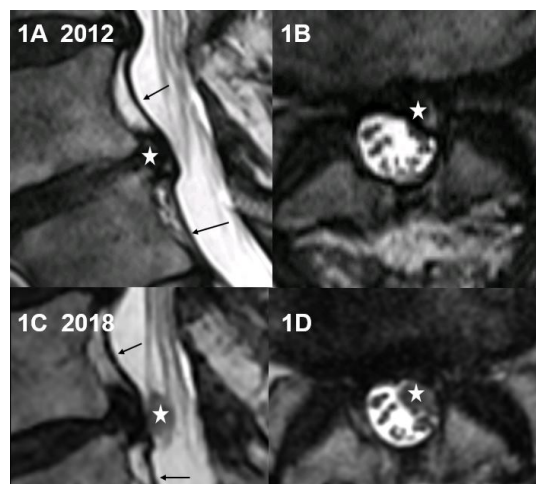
(1A) and (1B) are MRI images from 2012: sagittal T2, axial T2. They show subligamentar left posterolateral disc protrusion. PLL(thin arrows), disc protrusion (star). (1C) and (1D) are MRI images from 2018: intradural disc herniation (square) behind the PLL (thin arrows).
